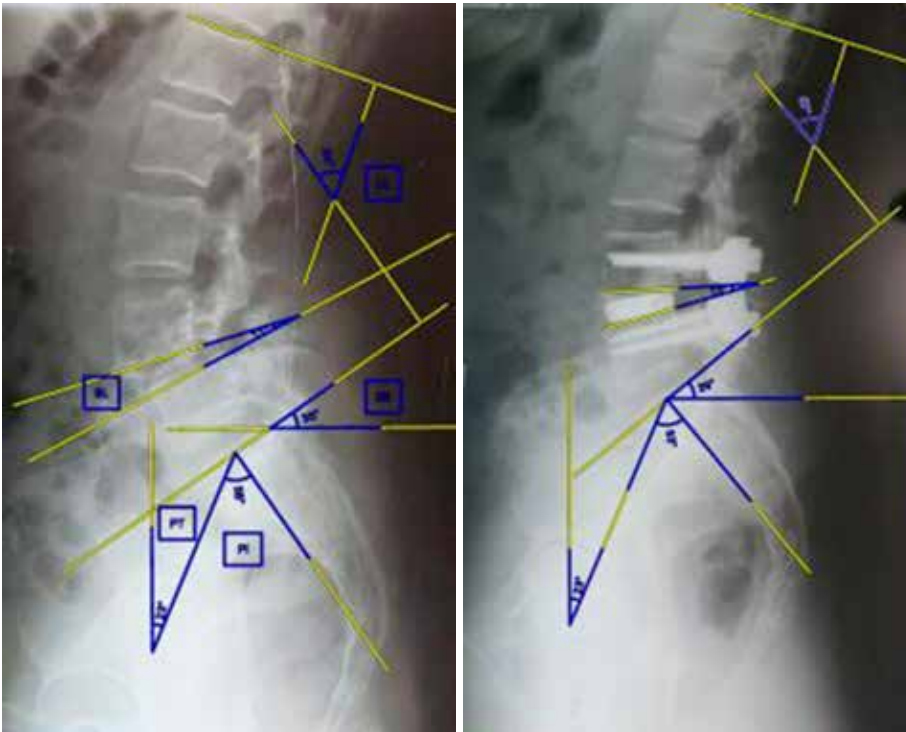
Radiographic control before and after surgery using the minimally invasive posterior interbody vertebral stabilization technique with titanium distraction cages
